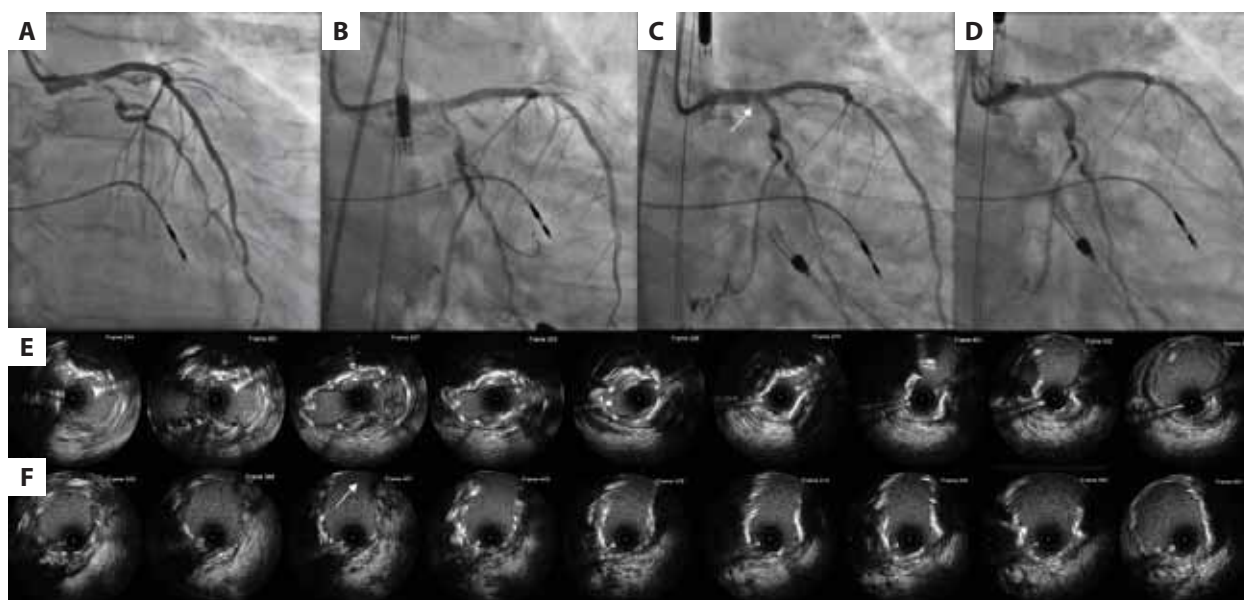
A. An anterior-posterior (AP) caudal angiographic view of the left coronary artery (LCA): significant stenosis of the left main and left circumflex arteries (LCX). B. AP caudal angiographic view of the LCA with Impella. C. Angiographic result after using a drug-coated balloon (DCB); protruding calcium nodules in the distal LM (the white arrow). D. Final angiographic view of the LCA after stent implantation. E. Intravascular ultrasound (IVUS) cross-sections of the LCX and the left main (LM) before shockwave intravascular lithotripsy (S-IVL). F. Final IVUS cross-sections of the anterior descending artery (LAD) in the proximal segment and the LM with a wide LCX ostium (the white arrow)
